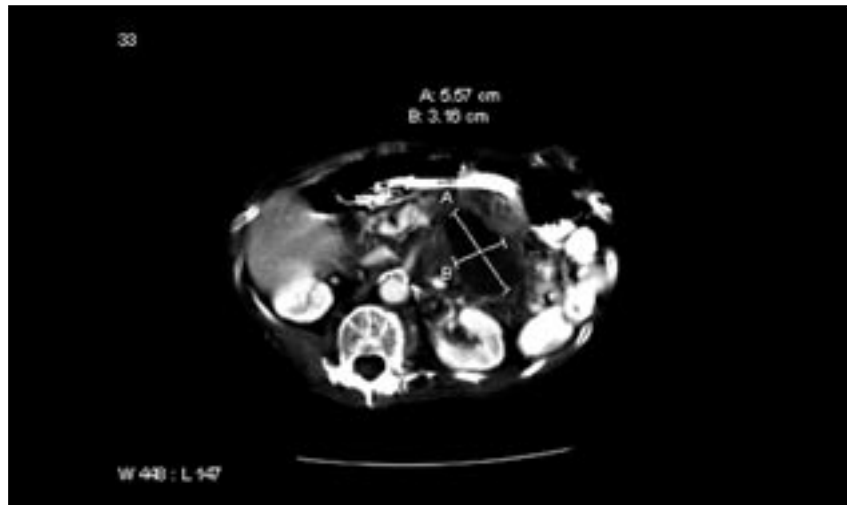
abdominal CT scan with contrast showing a pancreatic mass with 5.57 x 3.16 cm area of central necrosis.
